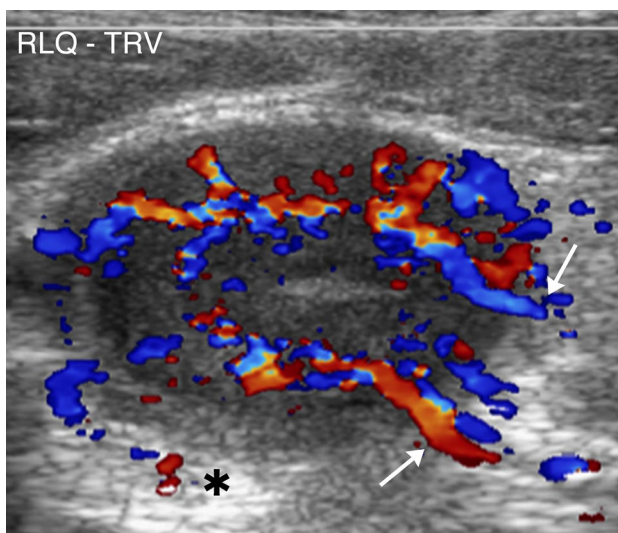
Active Crohn's disease in a 20-year-old male with abdominal pain and 8-year history of Crohn's Disease. Color Doppler image of the right lower quadrant in transverse plane demonstrates marked bowel wall thickening, (measuring > 10 mm), loss of normal mucosal striation, increased echogenicity of peri-enteric fat (asterisk), and hyperemia of the bowel wall with vessels extending to the mesentery, aka comb sign (white arrows)
